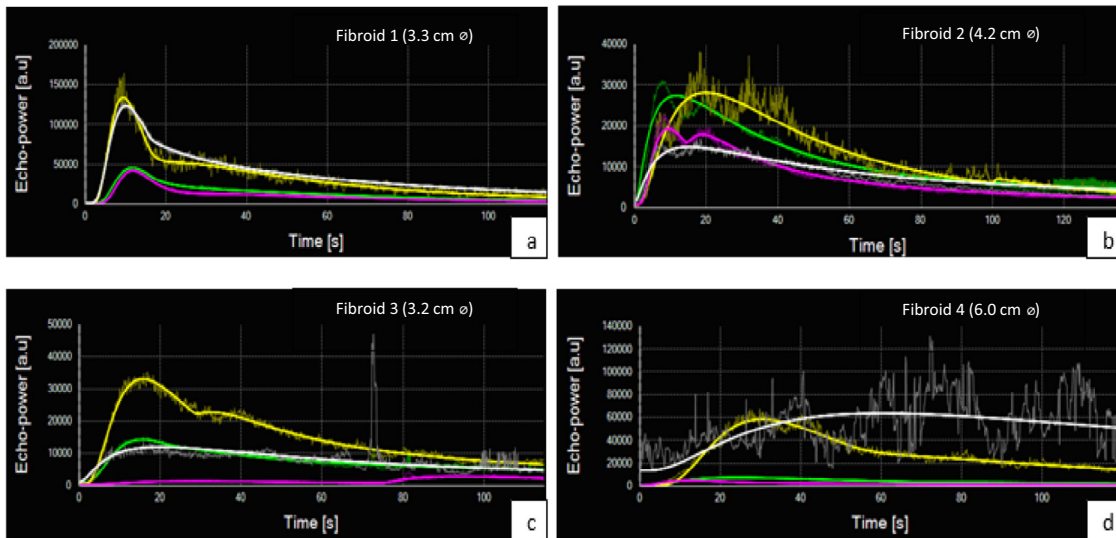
Time–intensity curves of all four fibroids. (a) Patient 1. (b) Patient 2. (c) Patient 3. (d) Patient 4. Colors correspond to the selected regions of interest on the contrast-enhanced ultrasound image: *green* = entire fibroid, *yellow* = peripheral part of fibroid, *pink* = central part of fibroid, *white* = myometrium adjacent to fibroid. ϕ = largest diameter of fibroid (cm) measured in sagittal plane.
